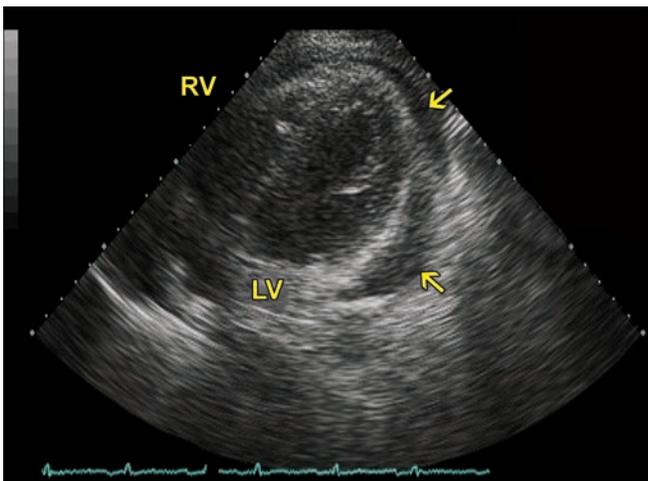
2D echocardiogram before pericardial effusion drainage.
